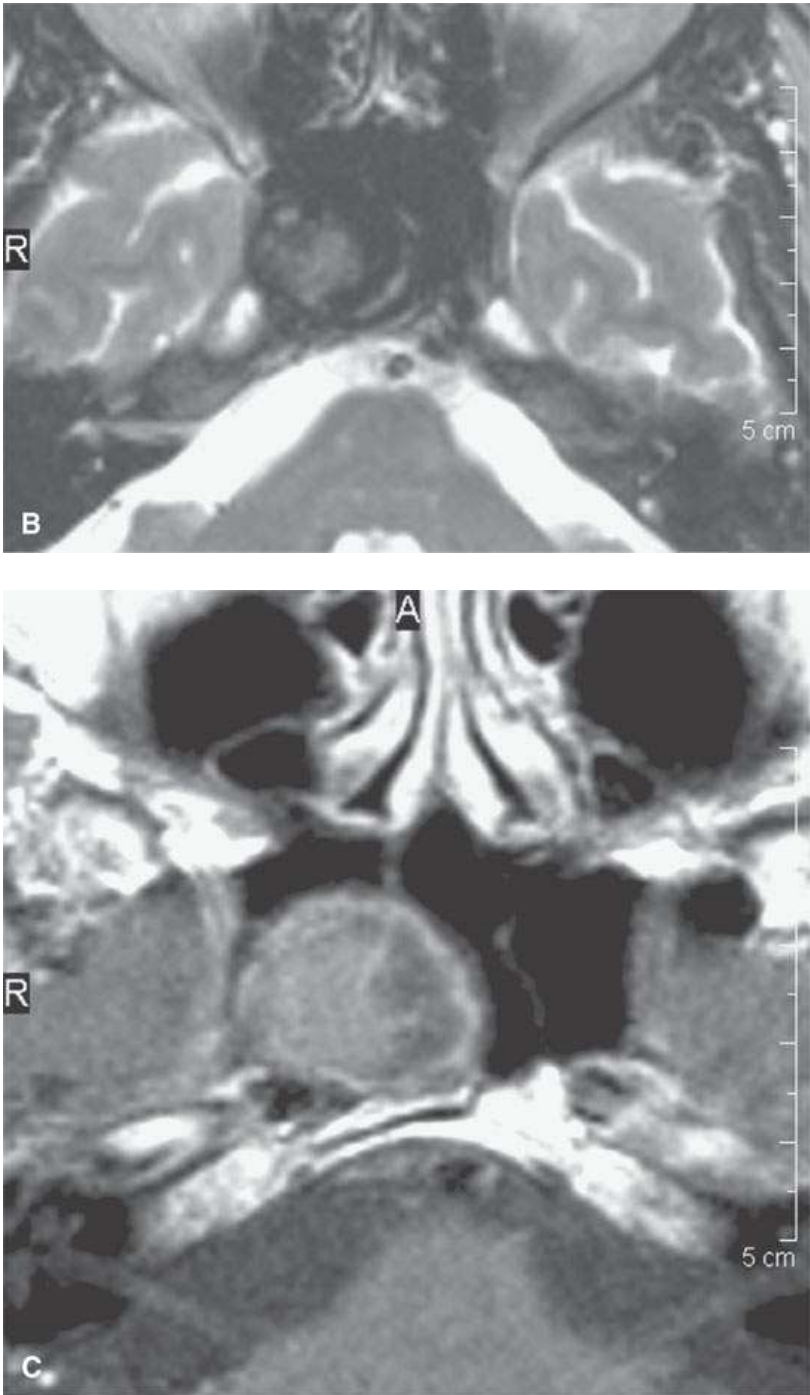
Cavernous segment aneurysm. The calcification suggesting wall and mural thrombus calcification is obvious on computed tomography. On the magnetic resonance imaging in (B) and (C), the findings are more ambiguous.
